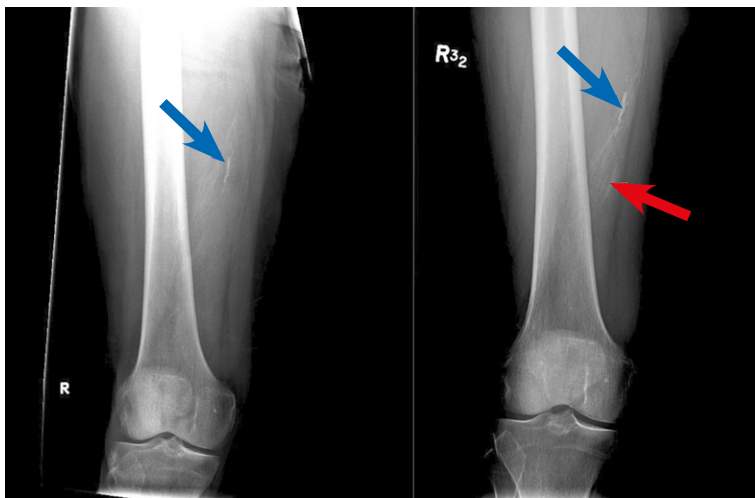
AP X-rays show previous vascular calcifications (Left-blue arrow) with no apparent masses at the site of injury at presentation. At 4 months follow up, there is increased calcifications noted (blue arrow) with expansion to the adjacent soft tissue area (red arrow) both are consistent with Heterotopic Ossification.
